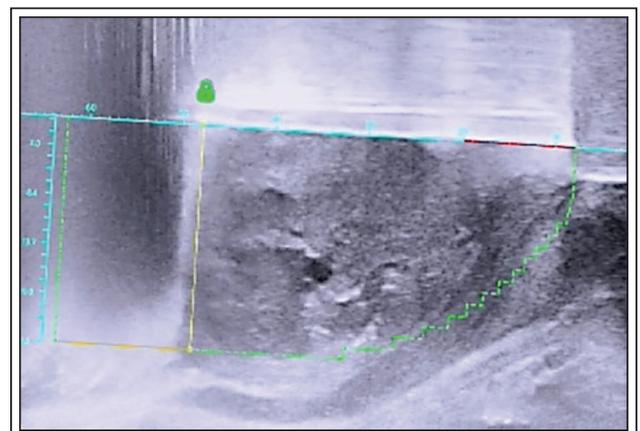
AQUABEAM System resection of tissue under ultrasound guidance.
